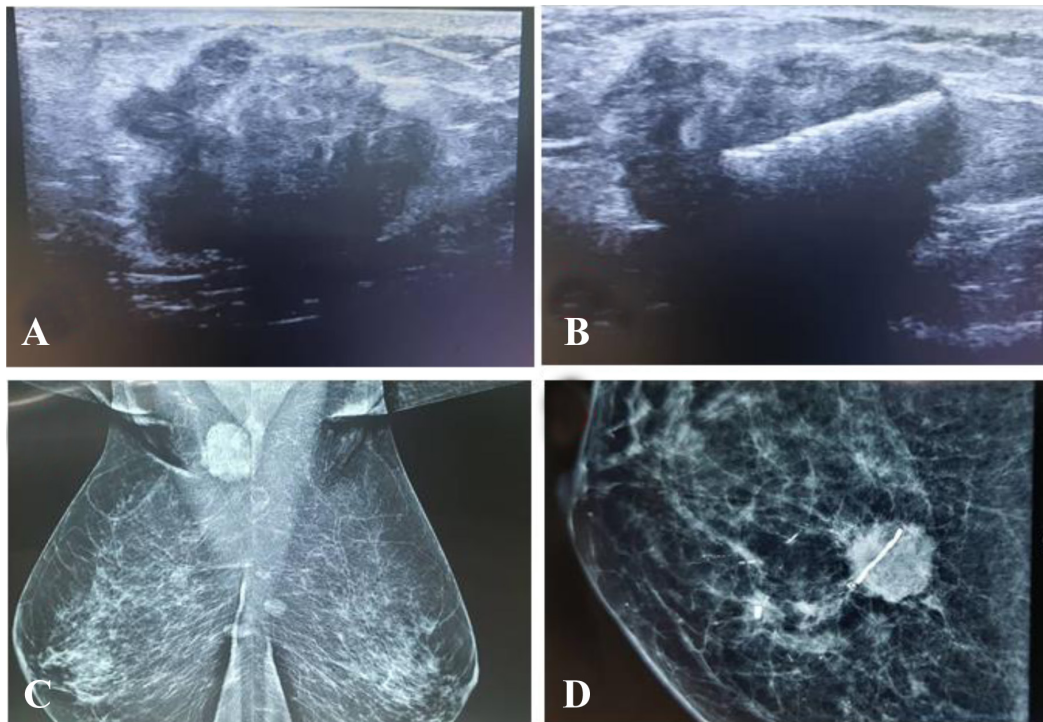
Mammography and ultrasound findings of the breast before and after marker placement. (A) Ultrasound before marker placement, (B) Ultrasound after marker placement, (C) Mammography before marker placement and (D) Mammography after marker placement.
